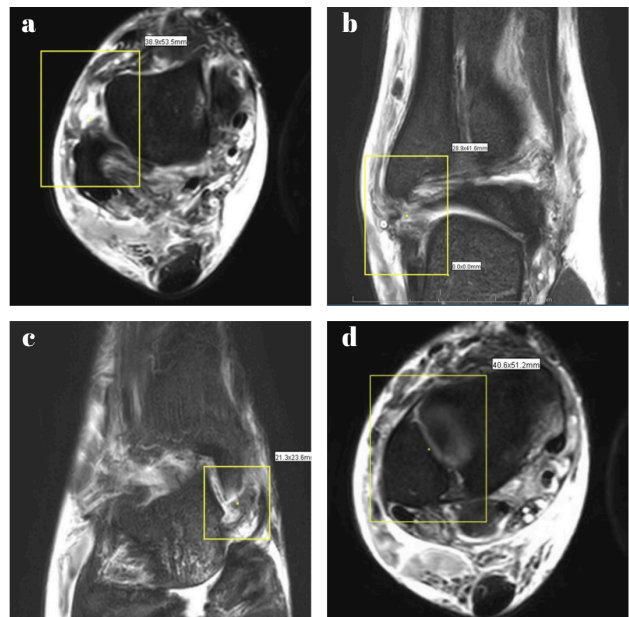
MRI on day 2 (a: ATFL rupture, b: CFL rupture, c: Deltoid ligament rupture, d: Intact syndesmosis)
